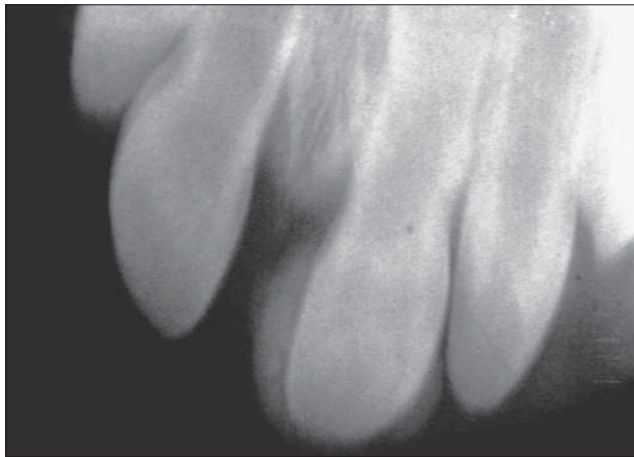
Occlusal radiograph, exhibiting fine, granular opacities around the crown of the central incisor
